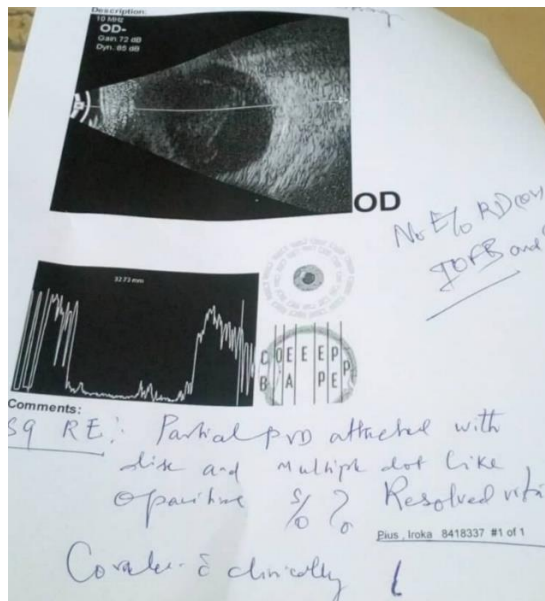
Ocular ultrasound while awaiting vitrectomy and phacoemulsification
